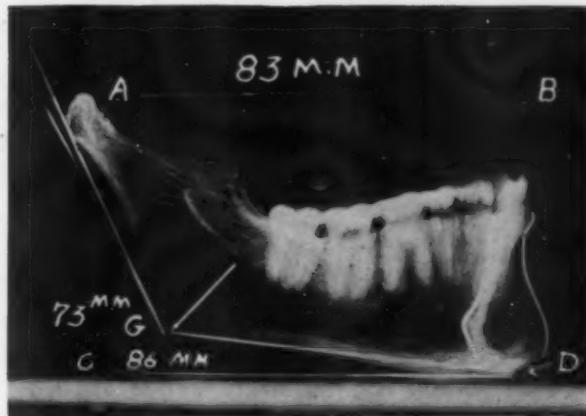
Lateral x-ray of mandible in fixed position showing projected measurements of wires AB, CD, GD, actual measurement of each wire being 83 mm. (X-ray taken by Dr. L. M. Ennis.)
